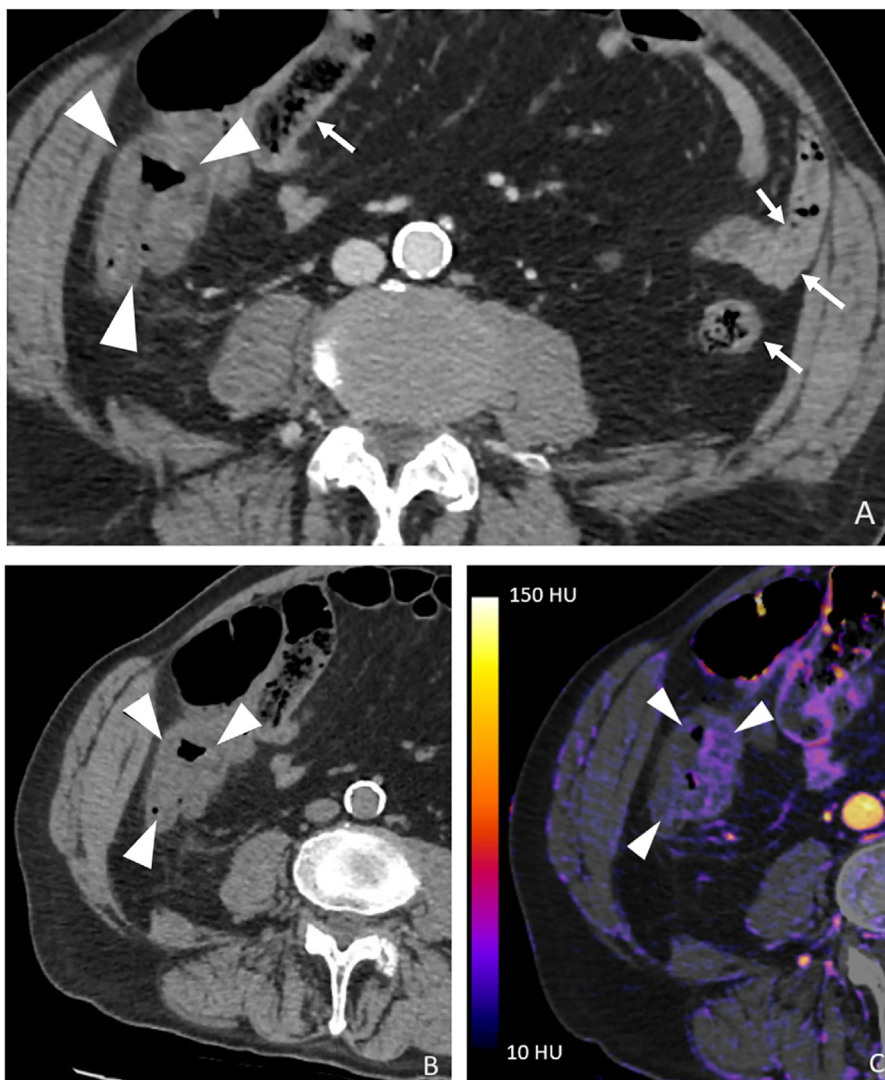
52-year-old woman with a clinical diagnosis of Crohn's disease presenting an acute flare. Axial portal phase CT image (A) and axial gray-scale iodine map (B) depicting segments of bowel wall thickening (arrowheads) and normally appearing bowel wall (thin arrows). Note the higher bowel wall enhancement in the pathologic segment measured at 98 HU compared to the normally appearing segment 85 HU.
